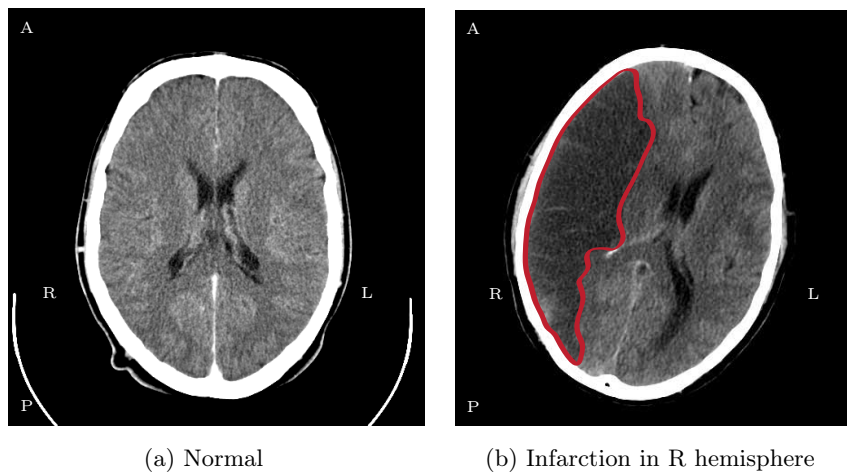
Axial slice of CT scans of the brain in normal and stroke condition. From (a) [https://commons.wikimedia.org/wiki/File:Computed_tomography_of_human_brain_\(18\).png](https://commons.wikimedia.org/wiki/File:Computed_tomography_of_human_brain_(18).png) and (b) <https://commons.wikimedia.org/wiki/File:Infarction.svg>.
